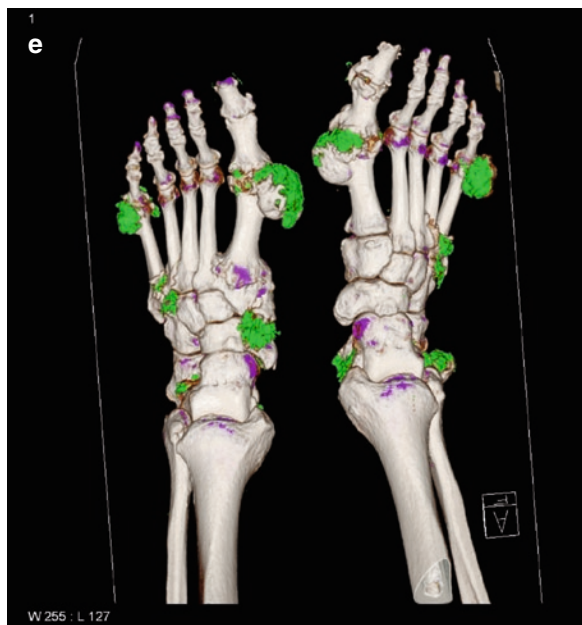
70 year old man who presented with cellulitis and pain in his right hand. Scans were ordered to rule out osteomyelitis. (a) Radiograph – demonstrates a destructive process centered along the second DIP. (b) 3D volume rendered, coronal reformatted DECT: surrounding the second DIP are MSU deposits (color
